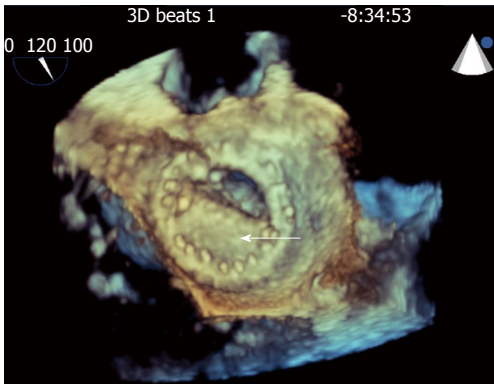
Still frames of 3-dimensional transesophageal echocardiographic rendering of the mechanical bi-leaflet mitral valve as visualized from the left atrial perspective during diastole showing fixed mitral leaflet (arrow).
